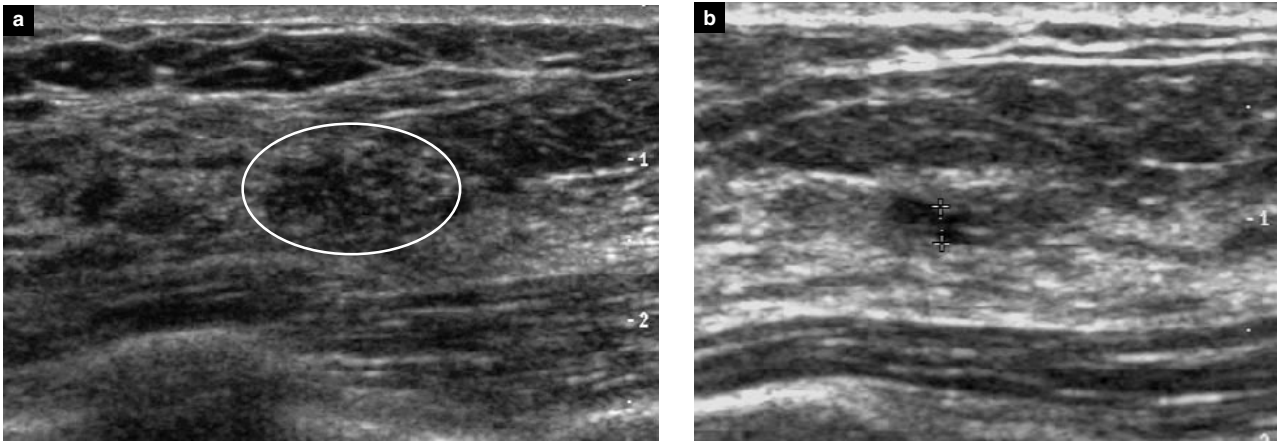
(a) Ultrasound image taken on the first postoperative day showing the site of the lesion as a region of low echogenicity with echogenic foci corresponding to air and hematoma. (b) After 3 months only a small structure can be identified at the site of the former lesion showing no signs of the shadowing that can be expected from scars following open surgery.
